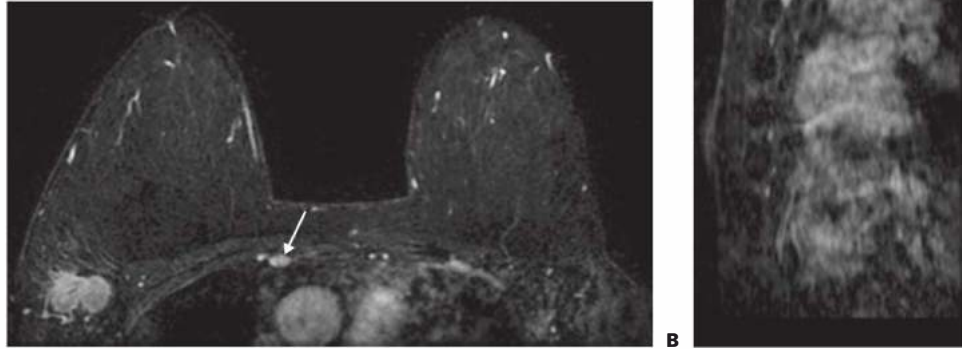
• A. Abnormal right internal mammary lymph node and right axillary lymphadenopathy seen on breast MRI axial T1 postcontrast subtraction series. B. Breast MRI. Sagittal T1 reconstruction demonstrating the abnormal internal mammary node. (Courtesy of Stephen Seiler, MD, University of Texas Southwestern Medical Center.)
